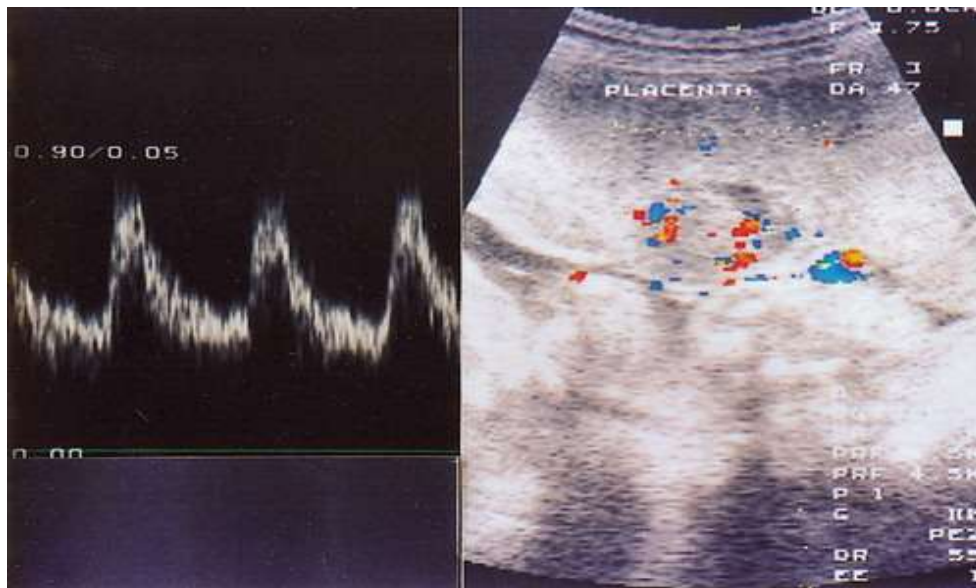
Doppler effect.
